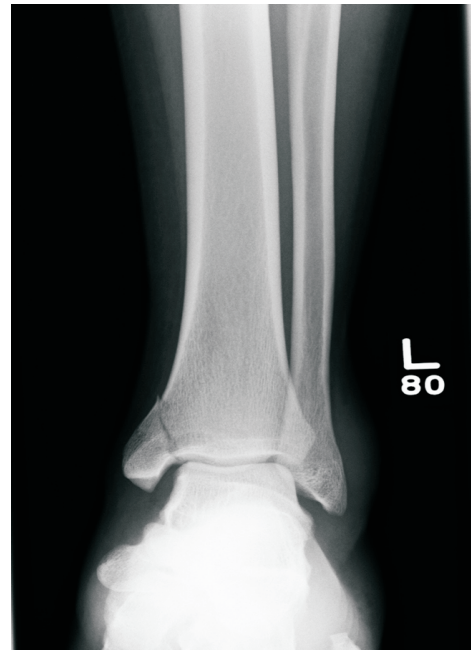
Anterior-posterior radiograph showing non-displaced fracture of medial malleolus.
